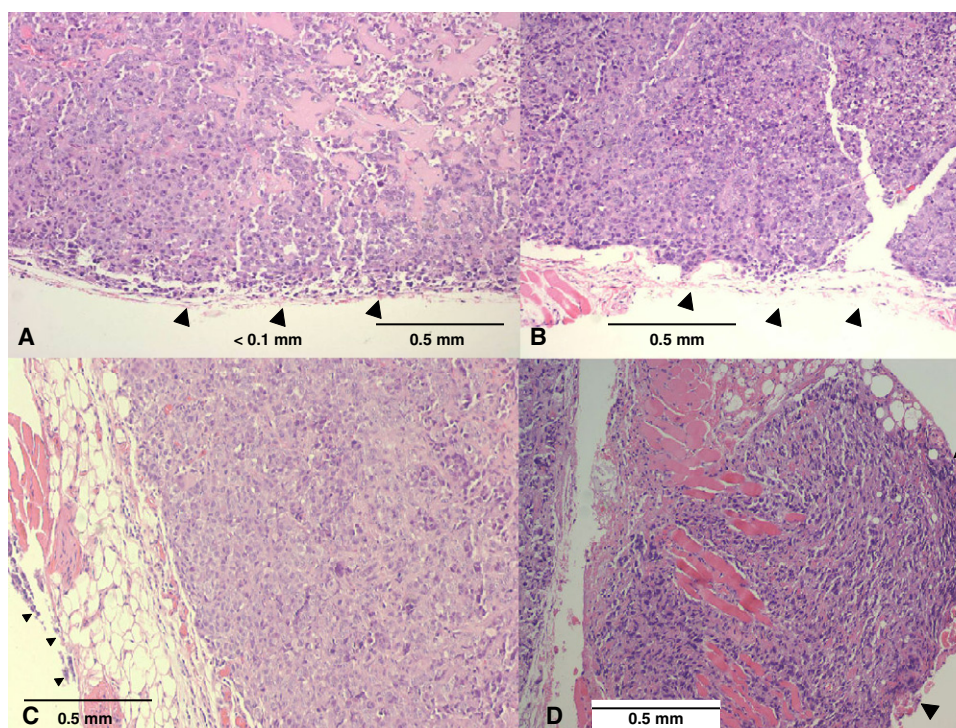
Pathology examination findings. (A) PSMA positive, margin negative. (B) PSMA negative, margin negative. (C) PSMA positive, margin negative. (D) PSMA negative, margin positive. Arrowheads indicate margins.
